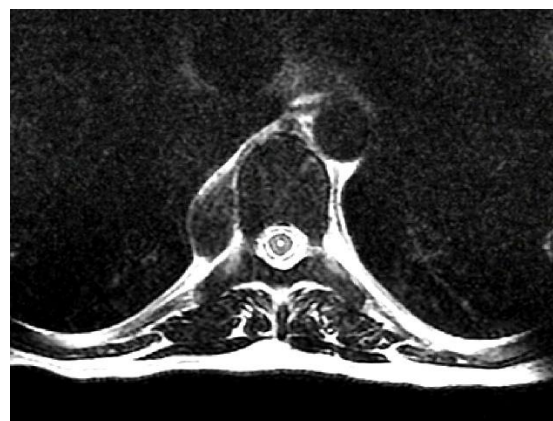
Axial T2W thoracic vertebra MRI scan shows well-circumscribed EMH in the right paraspinal area.
